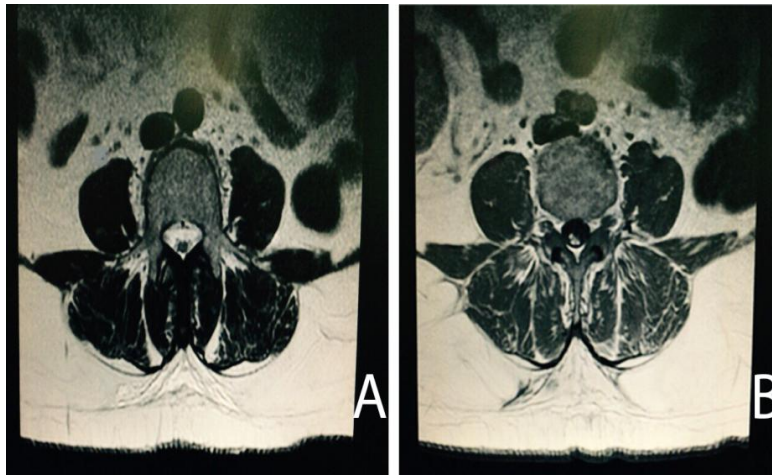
T2 MRI shows cross section tethered cord
